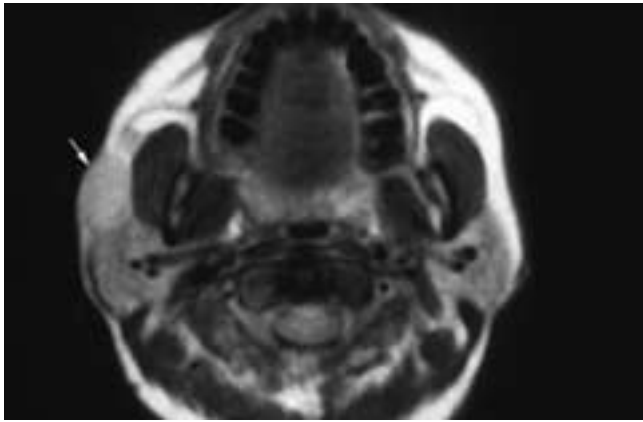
Axial proton density MR image shows an intermediate signal intensity well-delineated mass (*arrow*) arising in the anterior portion of the right parotid gland and overlying the masseter muscle. This patient had a fibrous histiocytoma.
